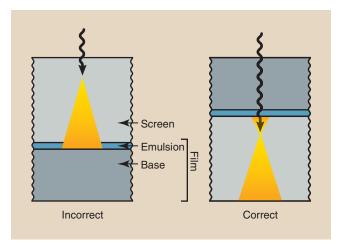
The correct way to load mammography film and position the cassette. Spatial resolution improves when the x-ray film is placed closest to the breast and between the x-ray tube and the radiographic intensifying screen.
